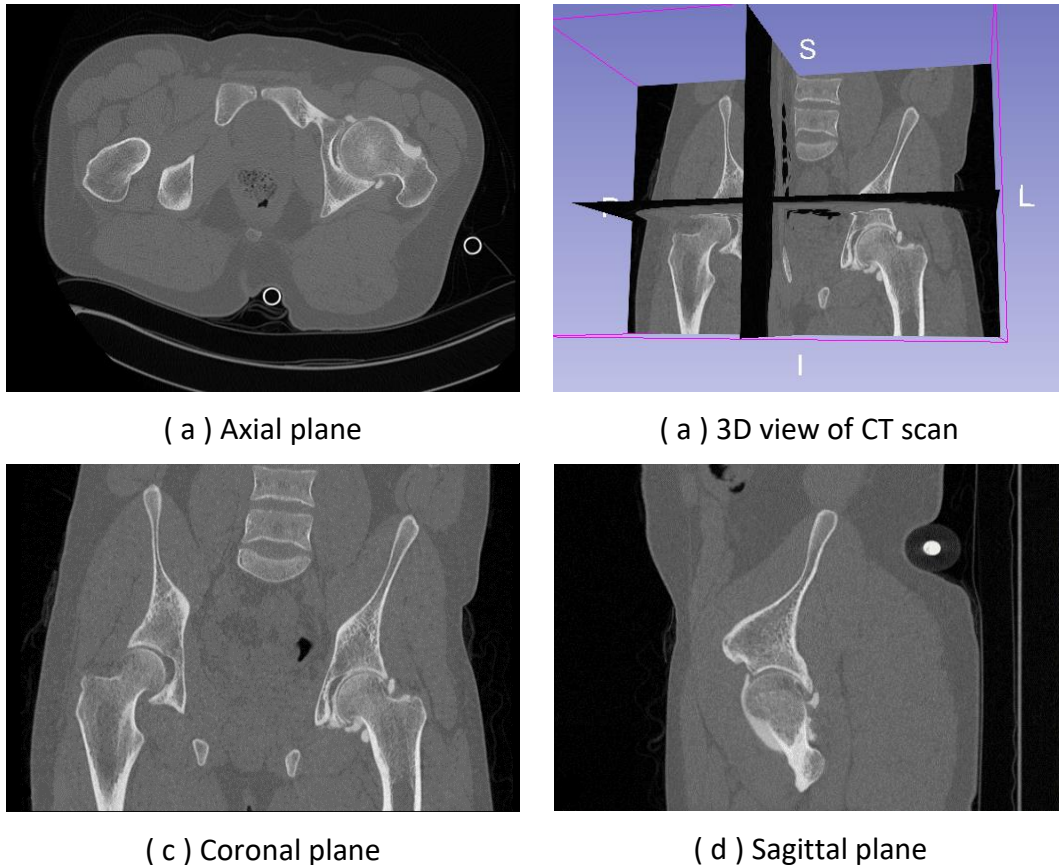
Example of the CT image used for DRR rendering
